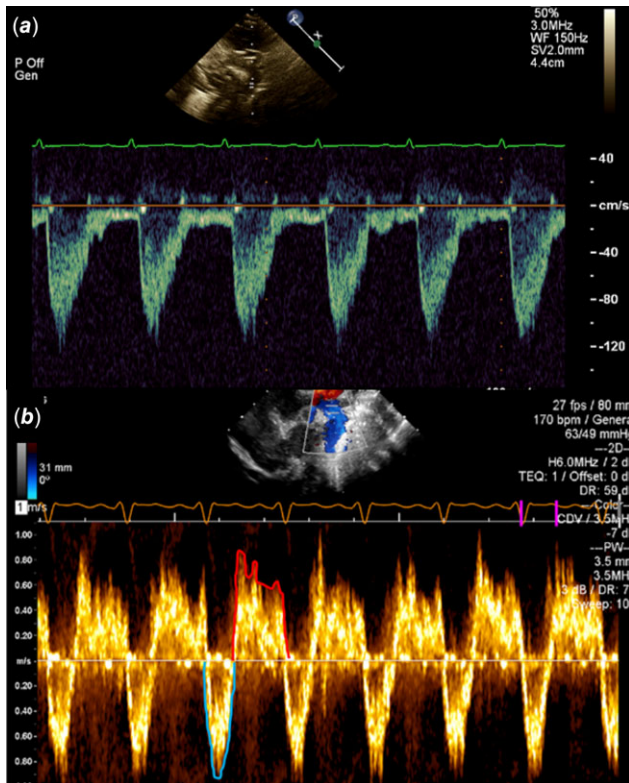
a*: normal pulse wave doppler of the transverse aorta with antegrade blood flow in systole and no retrograde diastolic flow. *b*: pulse wave doppler of the transverse aorta in neonatal vein of Galen aneurysmal malformation demonstrating significant diastolic flow reversal (red) with antegrade: retrograde VTI ratio of < 1 in this patient.
